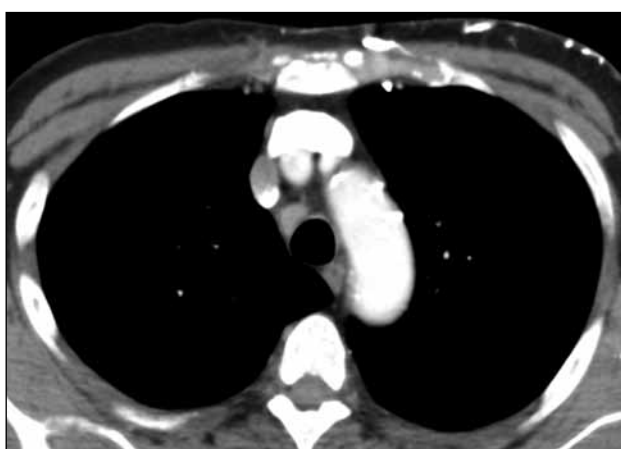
Enlarged mediastinal lymph node (ATS region 2R) in a 73-year-old patient having colorectal cancer with some peripheral pulmonary nodules suspicious for metastases. A lymph node in ATS region 2R is well-defined and oval in shape. Endobronchial ultrasound-guided transbronchial needle aspiration revealed lymphadenopathy with deposition of anthracotic pigment (multislice computed tomography 64 x 0.75-mm slice collimation, tube voltage 120 kV, axial reconstruction).
